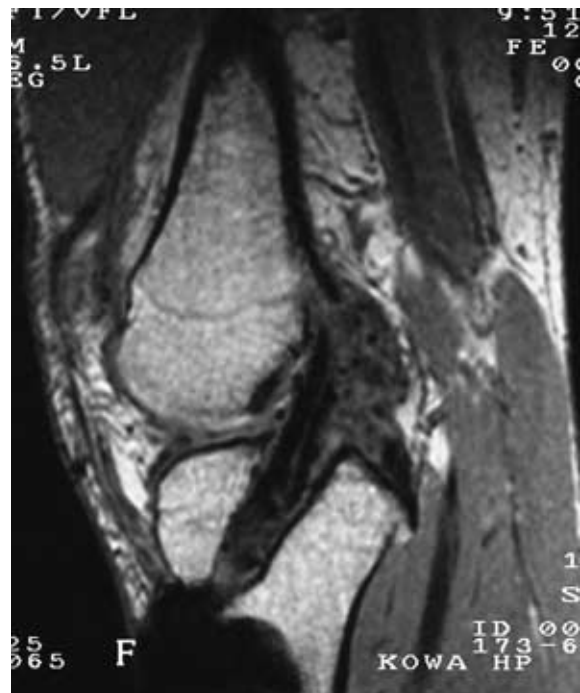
MRI (3D-FT) findings at 4.5 months after operation showed a wide low signal line in the sagittal view.
